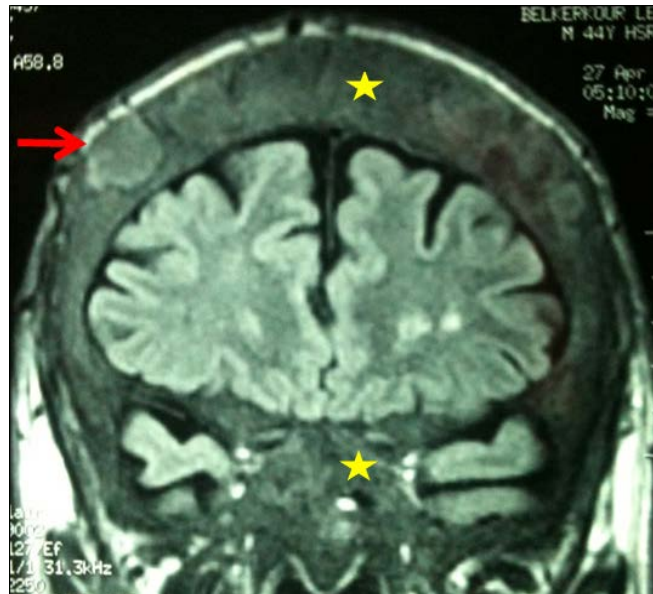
Cranioencephalic and orbital MRI in coronal section (Flair sequence) showing a brown tumor of the vault of the skull (red arrow) and thickening of the diploe and the base of the skull (yellow star).
